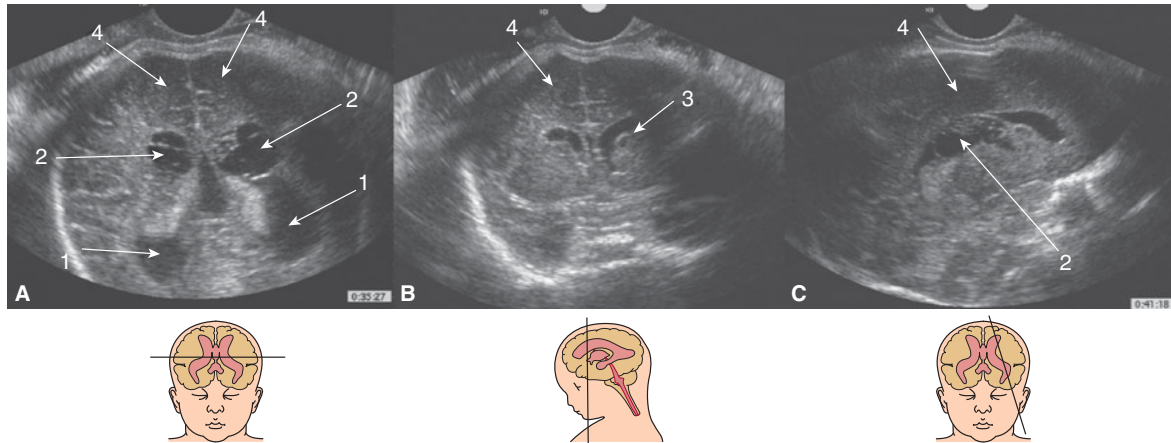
CMV in a fetus at 35 postmenstrual weeks; (A) axial, (B) coronal, (C) sagittal. The mother was CMV seropositive during the first trimester and was referred because of ventriculomegaly (1) at a routine ultrasound (US) examination. Bilateral large intraventricular cysts (2) and small periventricular pseudocysts (3) are depicted. The sulci and gyri are not observed due to white matter involvement (4).
